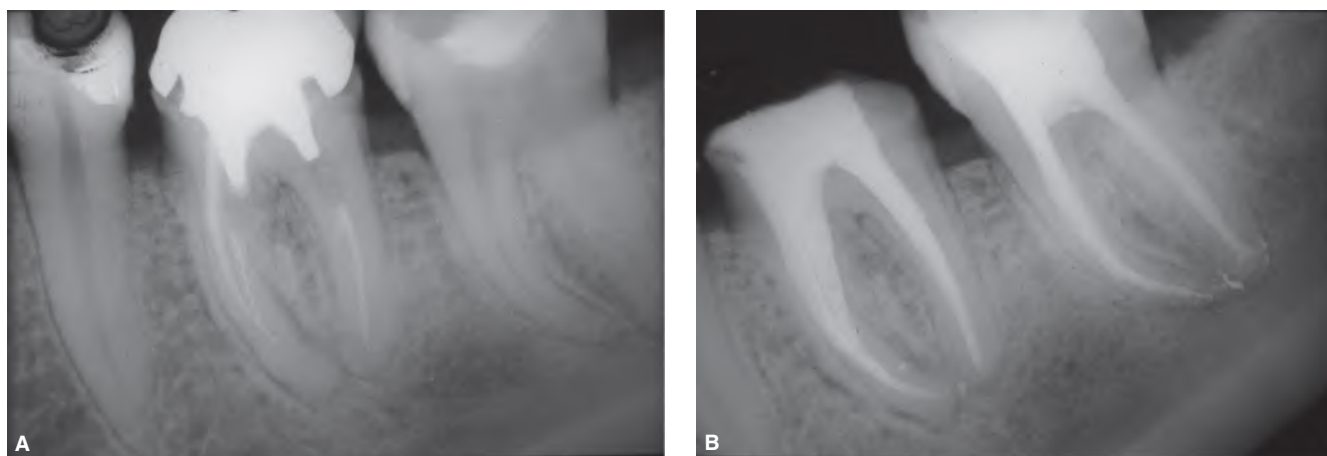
A. Retreatment is indicated on the mandibular first molar. In contrast to the second molar, many coronal and intracanal obstacles are present. B. A post-operative radiograph demonstrates the two treatments completed.
